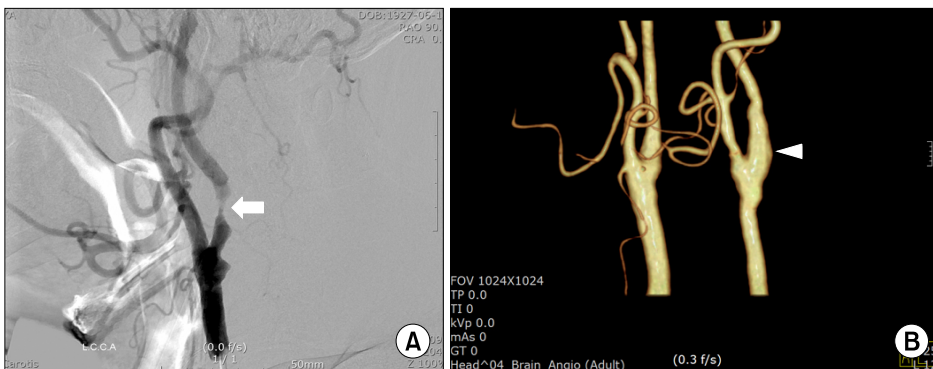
(A) Preoperative four-vessel angiogram and (B) postoperative computed tomography carotid angiogram. The carotid stenosis (white arrow) was repaired with endarterectomy and patch angioplasty (white arrowhead).
